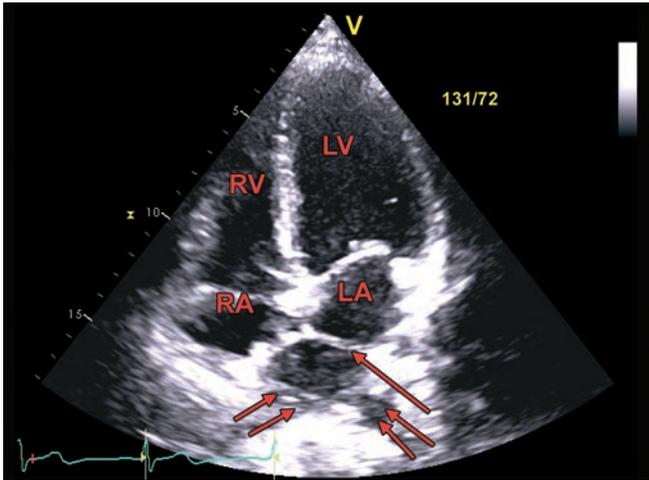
Apical 4-chamber view showing the membrane dividing the left atrium into two chambers (arrow). Note the pulmonary veins draining into the proximal chamber (double arrow).
